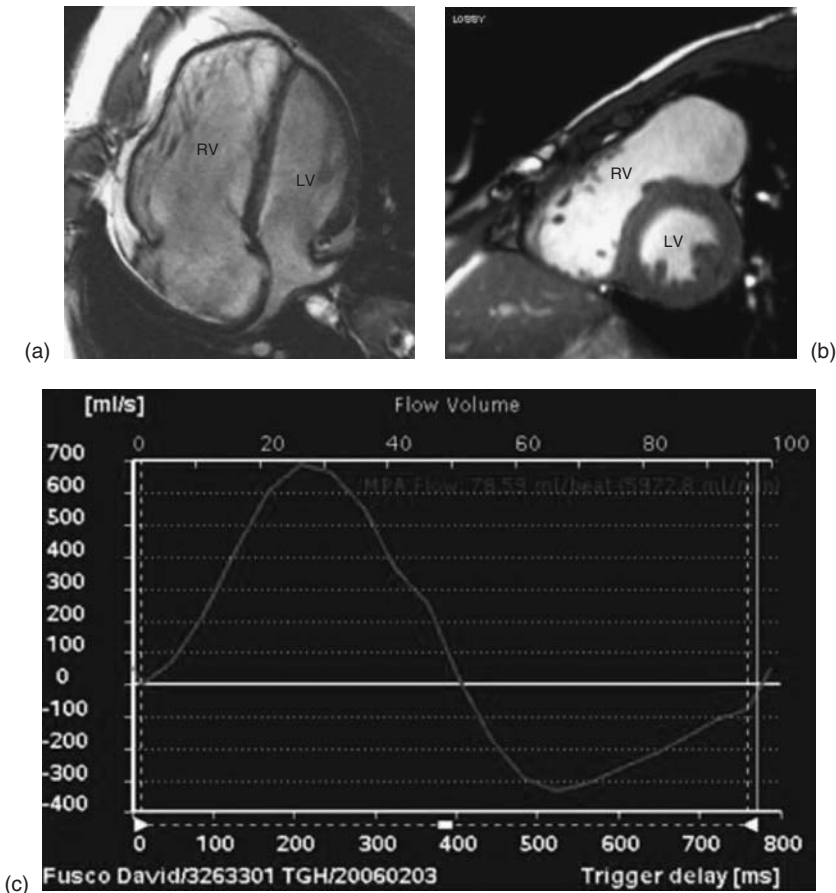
Still images from cine cardiac magnetic resonance four-chamber (a) and short axis (b) views of a dilated right ventricle in a patient with repaired tetralogy of Fallot and significant pulmonary regurgitation. Velocity-encoded cine magnetic resonance imaging (c) of a flow-velocity-time curve demonstrating significant pulmonary regurgitation. RV, right ventricle; LV, left ventricle.
